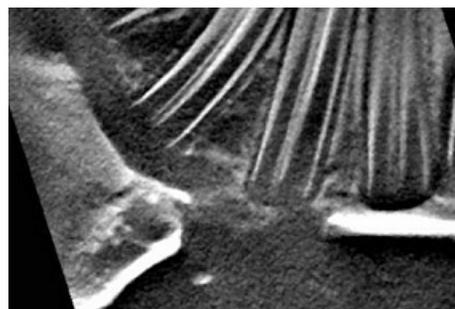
The slightly elevated X-ray density mass at the bone marrow side (iCT at one week).
